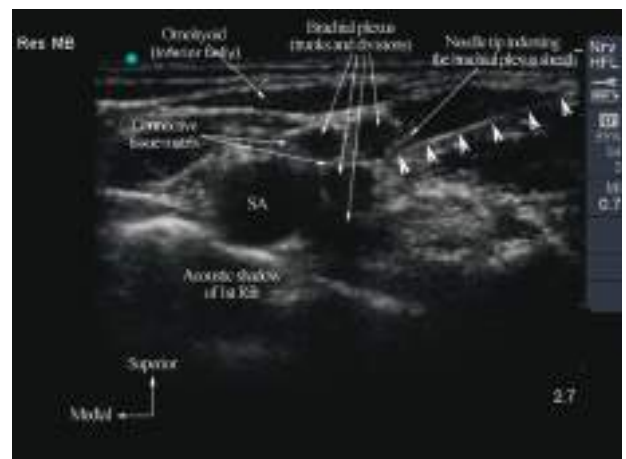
Transverse sonogram showing the sonoanatomy of the brachial plexus at the supraclavicular fossa. The trunks and divisions of the brachial plexus are seen as multiple hypoechoic round to oval structures lying superolateral to the subclavian artery (SA). Also note the hyperechoic layer of connective tissue external to the brachial plexus elements, the “brachial plexus sheath,” which is being indented by the tip of the block needle (white arrow heads). The connective tissue matrix in between the nerves appears hyperechoic.
